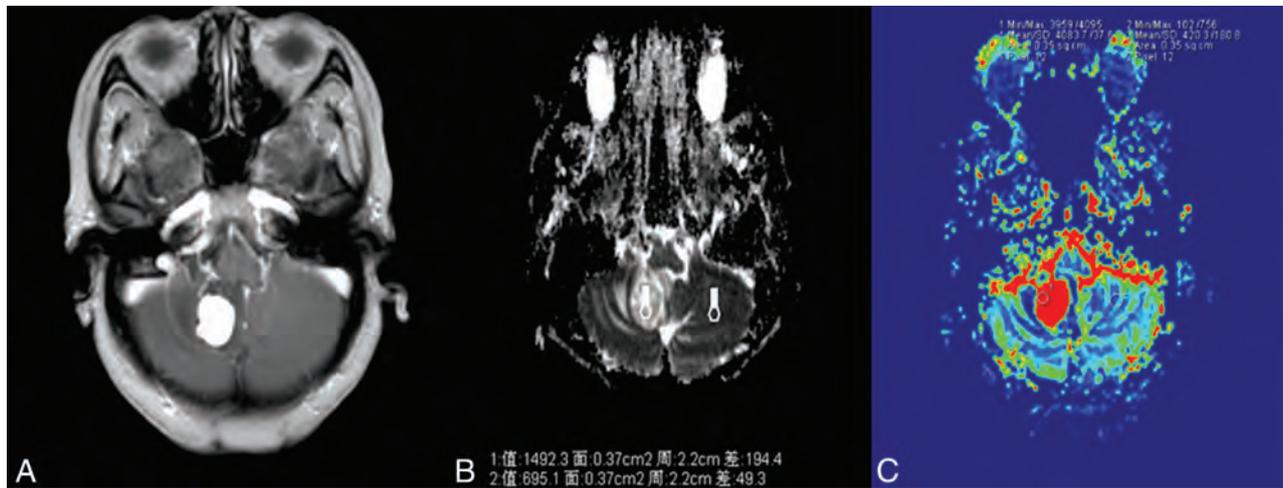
A 54-year-old woman with hemangioblastoma. *A*, Contrast-enhanced axial T1-weighted image demonstrates an obvious contrast-enhancing lesion on the right cerebellar hemisphere. *B*, A corresponding ADC map shows the tumor with an increased ADC value ($ADC_{min} = 1492.3 \times 10^{-3} \text{ mm}^2/\text{s}$, $rADC = 2.15$). *C*, Correlative color CBV image shows significant elevated perfusion with the calculated $rCBV_{max}$ of 9.72.
